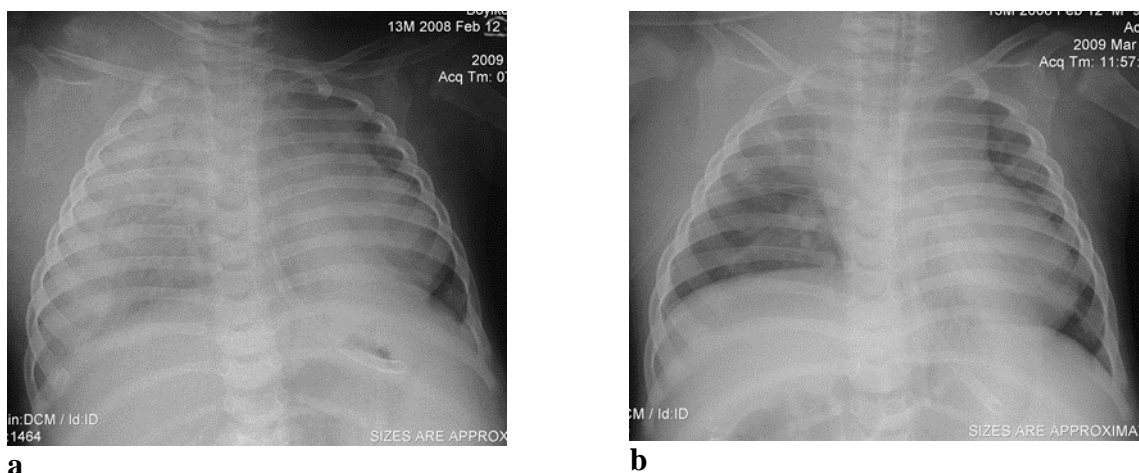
Right-sided hemothorax. Plain chest X-ray before (a) and after (b) pleural puncture
